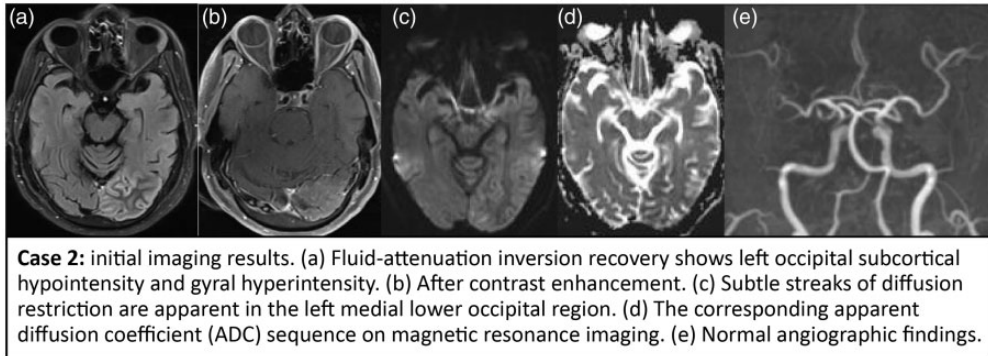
Case 2: initial imaging results. (a) Fluid-attenuation inversion recovery shows left occipital subcortical hypointensity and gyral hyperintensity. (b) After contrast enhancement. (c) Subtle streaks of diffusion restriction are apparent in the left medial lower occipital region. (d) The corresponding apparent diffusion coefficient (ADC) sequence on magnetic resonance imaging. (e) Normal angiographic findings.
